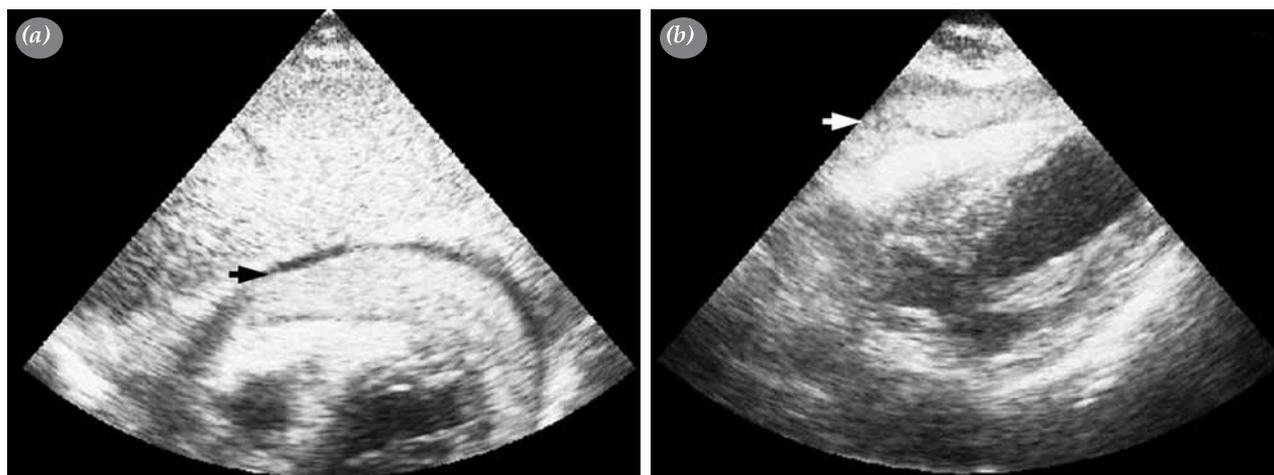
Transthoracic echocardiography showing pericardial tamponade (arrow), in (a) oozing type; and (b) 3 cm blow-out type of free wall rupture.
